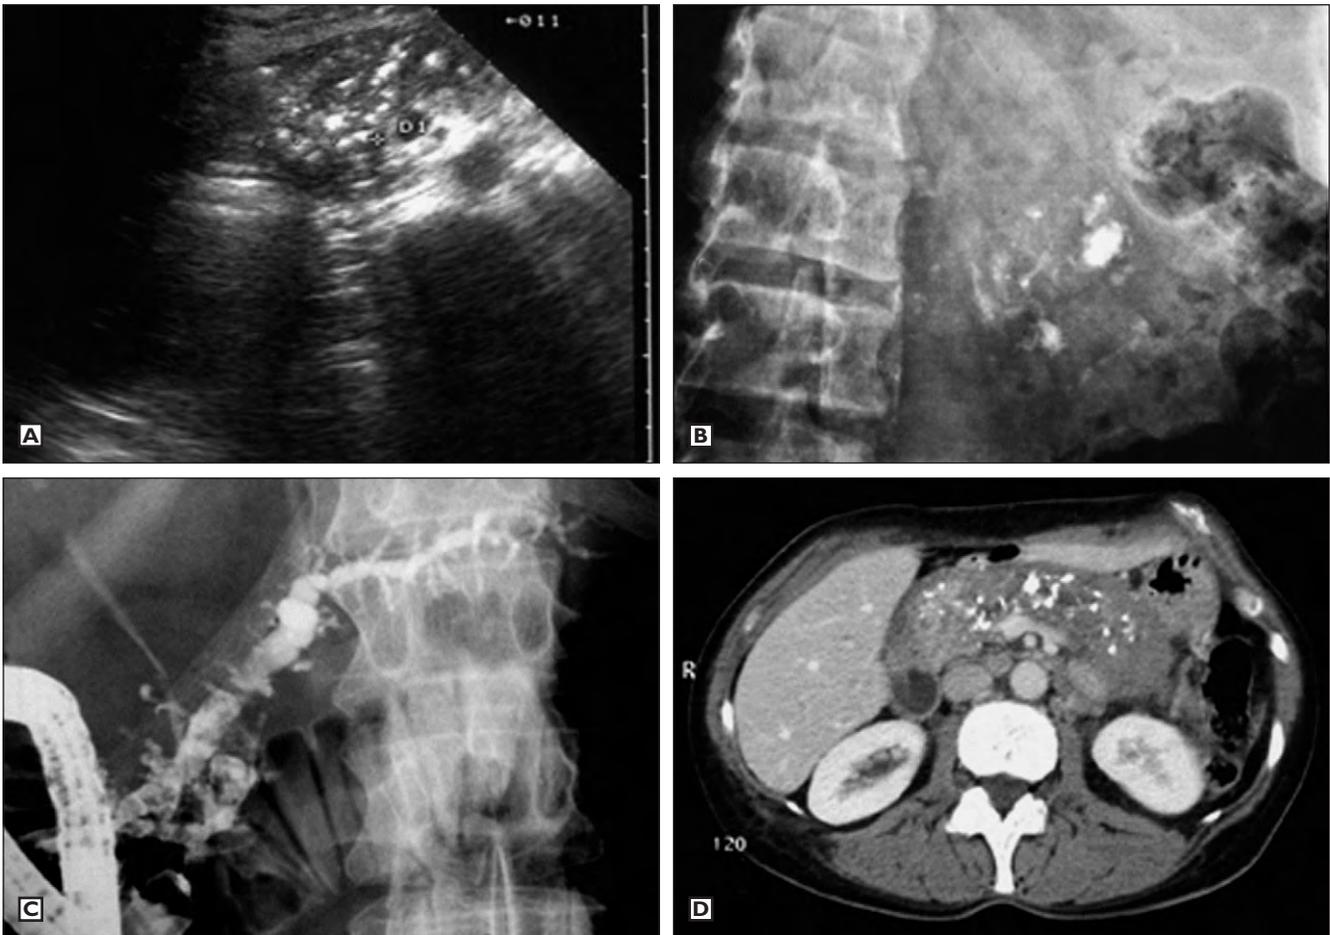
• Typical morphological signs of advanced calcifying chronic pancreatitis. (A) Transabdominal ultrasound with numerous calcifications in the pancreatic head. (B) Plain abdominal radiography with multiple calcifications. (C) Endoscopic retrograde cholangiopancreatography (ERCP) with dilated pancreatic duct and filling defects as well as more than three altered side branches displaying irregularities. In the head of the pancreas a filling defect in the main pancreatic duct can be observed most likely resembling a pancreatic duct stone. (D) Contrast enhanced computer-tomography with an enlarged pancreatic gland, dilated pancreatic main duct and numerous calcified spots.
